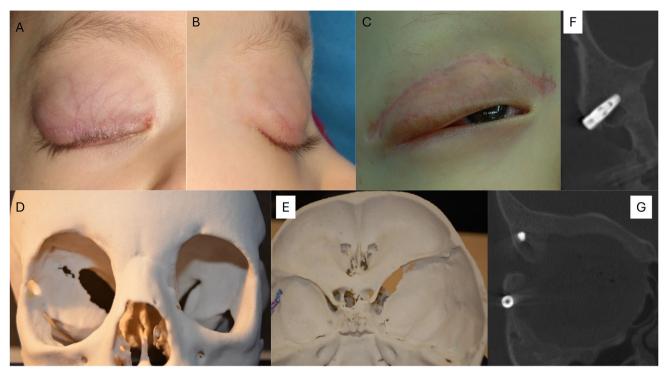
En-face image of the affected right eye (A) and lateral view at the first examination (age: two years and two months) (B). Notable findings include ptosis, an enlarged upper eyelid, and clear vascularization of the upper eyelid. (C) Image of the eye after tumor debulking, reduction of the upper lid's vertical dimension, and completion of chemotherapy, prior to orbital exenteration. (D) Three-dimensional model of the skull in frontal view, showing the typical enlargement of the orbit commonly found in congenital/infancy orbital plexiform neurofibromas. The superior orbital fissure is significantly enlarged, and the infraorbital rim is dislocated caudally. (E) The top view of the skull model shows enlargement of the middle cranial fossa on the right side, an enlarged superior orbital fissure, and dysplastic sphenoid wings. The dysplasia of the sella with an enlarged left optic canal is noticeable. The width of the spheno-occipital suture is within the normal range for the patient's age. (F) Intraoperative radiographic verification of the orbital implant positions for the planned epithesis retention is shown in the lateral and anterior-posterior (G) projection of the right orbit.
